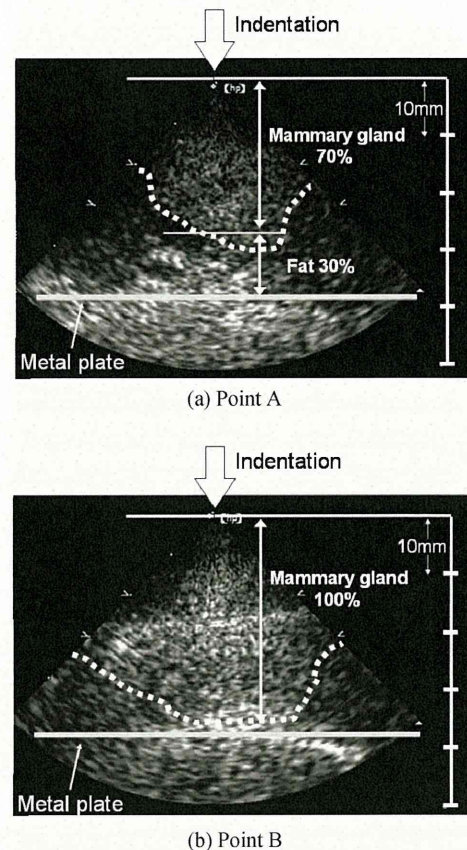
Ultrasound images of hog breast at each point
